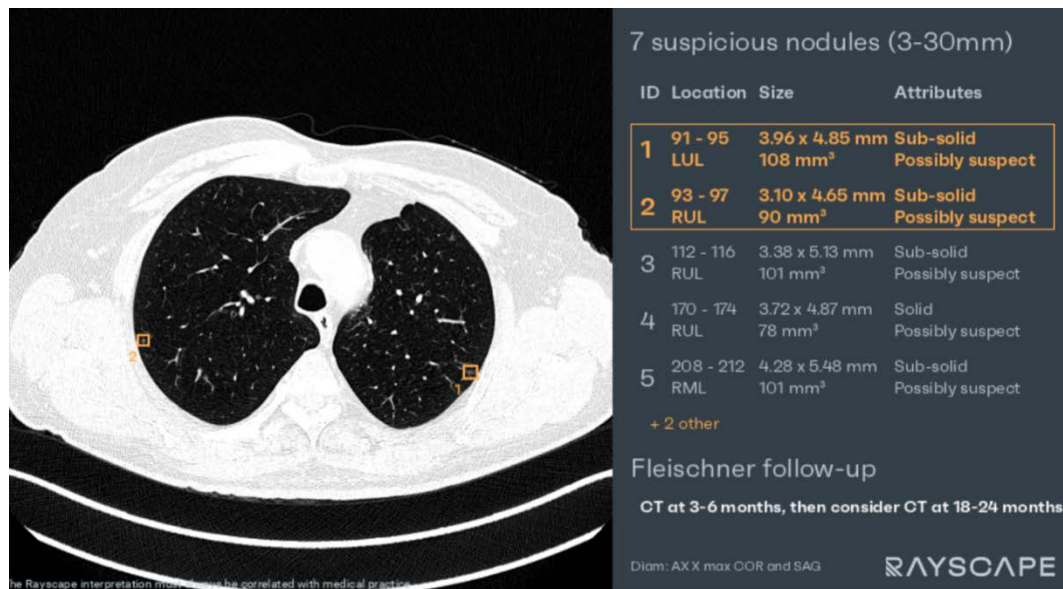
Data report (AI-assisted detection of multiple pulmonary nodules with characterization and prioritization). Axial chest CT image demonstrating automatic detection of multiple pulmonary nodules highlighted with bounding boxes (left). The AI-generated interface (right) provides a structured overview of all detected lesions, including anatomical location, size measurements, and attenuation characteristics, with emphasis on subsolid nodules. Suspicious lesions are prioritized within the list, and guideline-based follow-up recommendations according to Fleischner criteria are displayed, supporting risk stratification and clinical decision-making.
